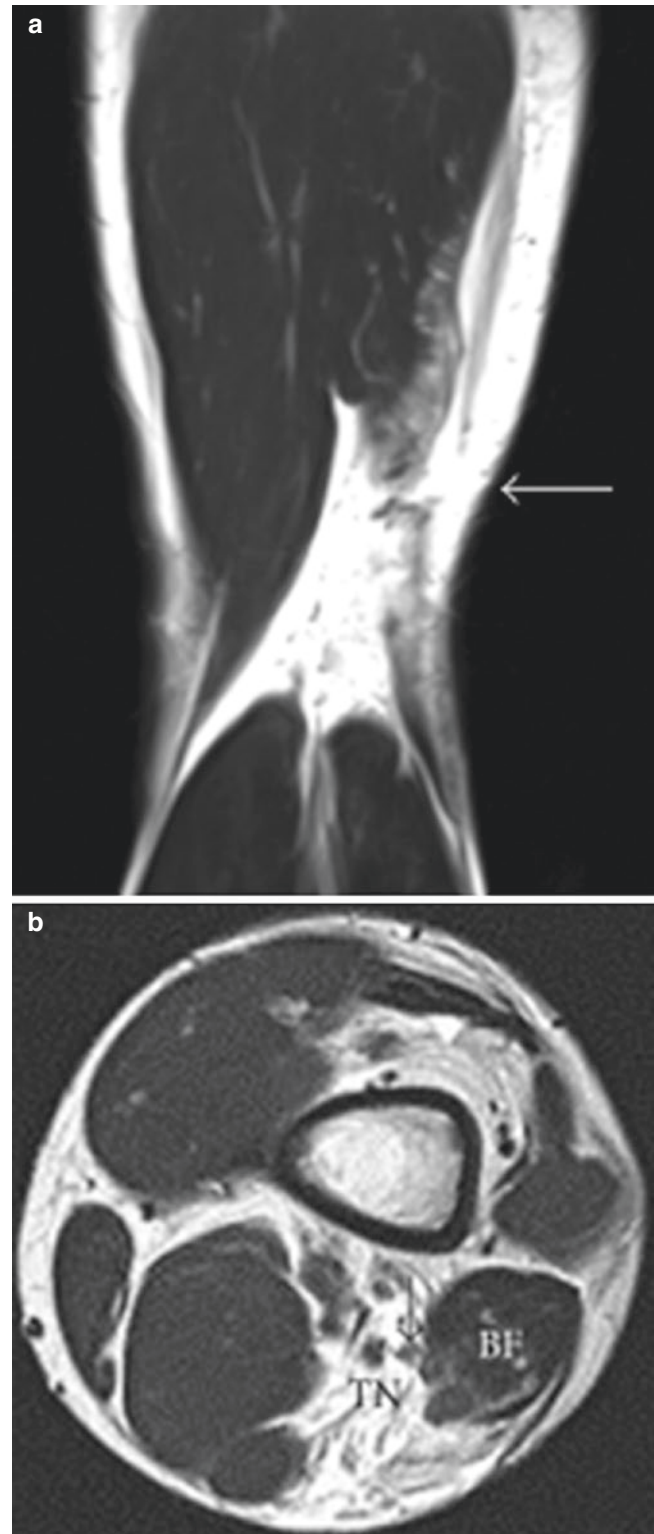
T2-weighted MRI of a complete rupture of the distal biceps femoris tendon at the musculotendinous junction. (Reproduced from Aki Fukuda et al. [65])
